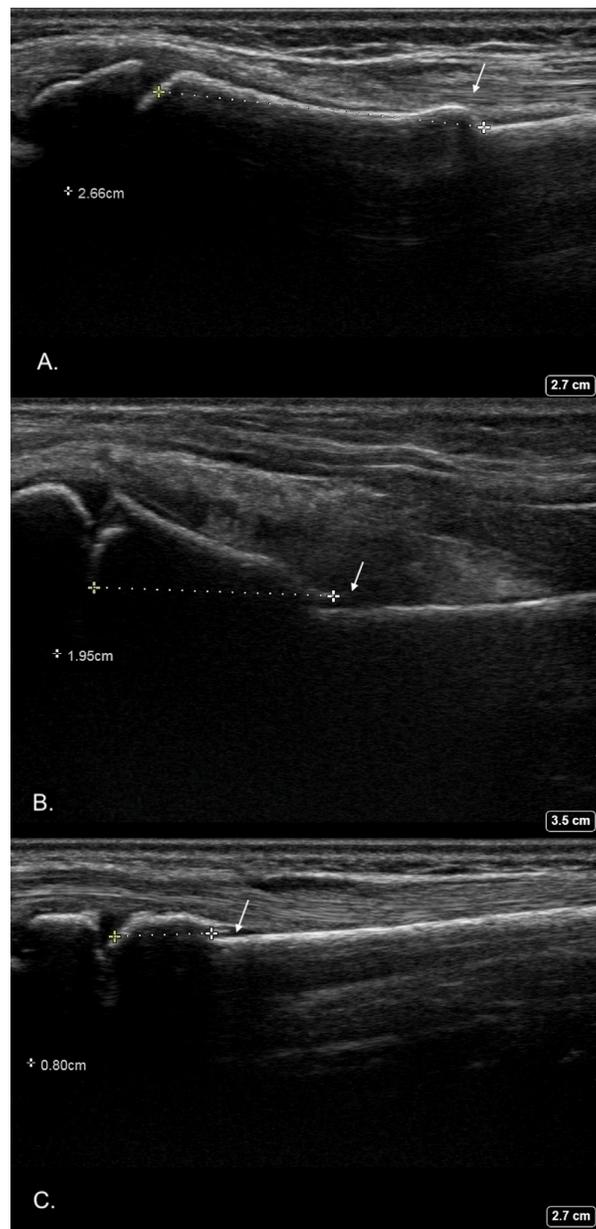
Point-of-care ultrasound (POCUS) images revealing the fracture–physis distance measurement for a buckle fracture (A), an incomplete fracture (B) and a Salter–Harris II fracture (C).
